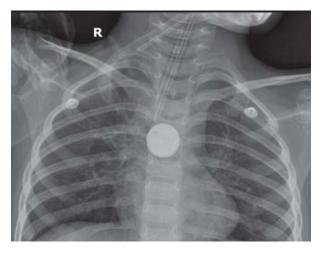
Chest radiograph showing a coin-shaped opacity in midthorax with double ring or halo sign
